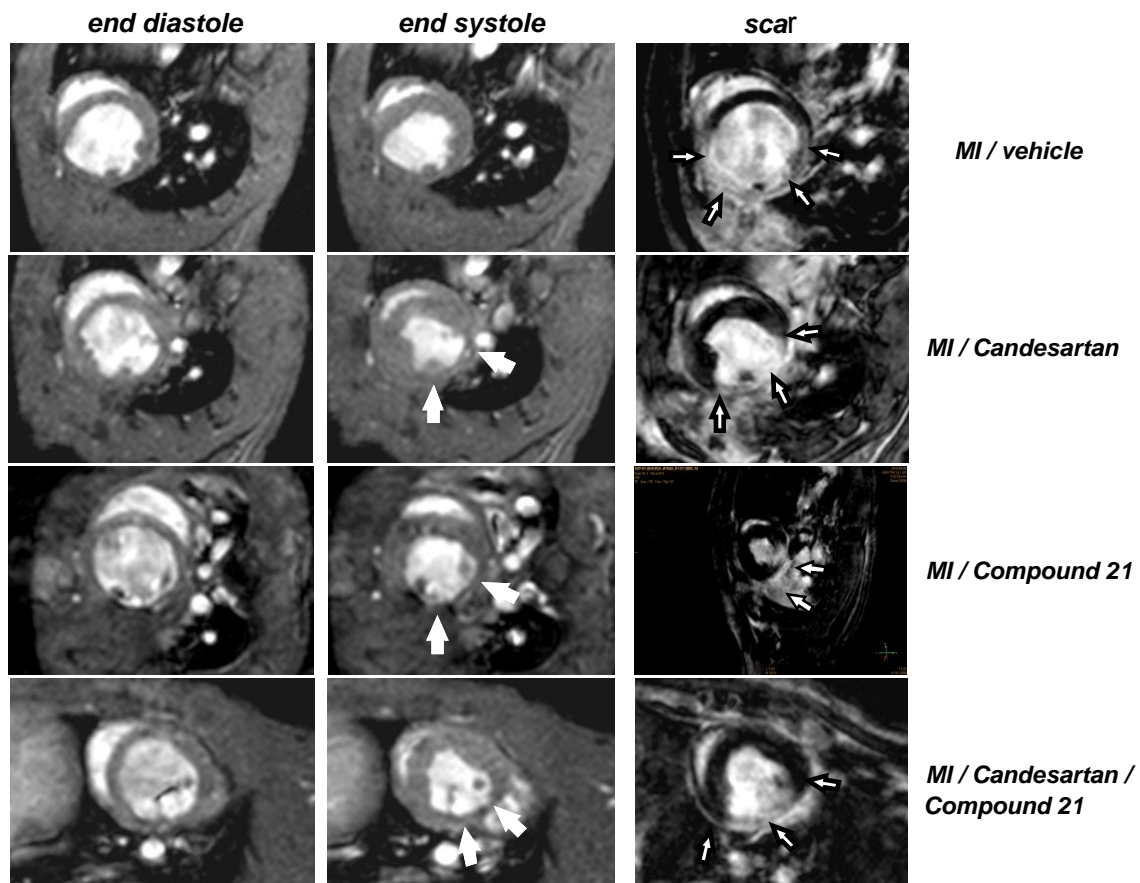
Representative cine MR images (left, enddiastolic frame; right: endsystolic frame) and corresponding delayed enhancement MR imaging. White arrows: segmental wall motion abnormalities; black-rimmed white arrows: segmental extent of scar tissue (i.e. brightly signal- enhanced myocardium on post-contrast images with non-scarred myocardium appearing black).
